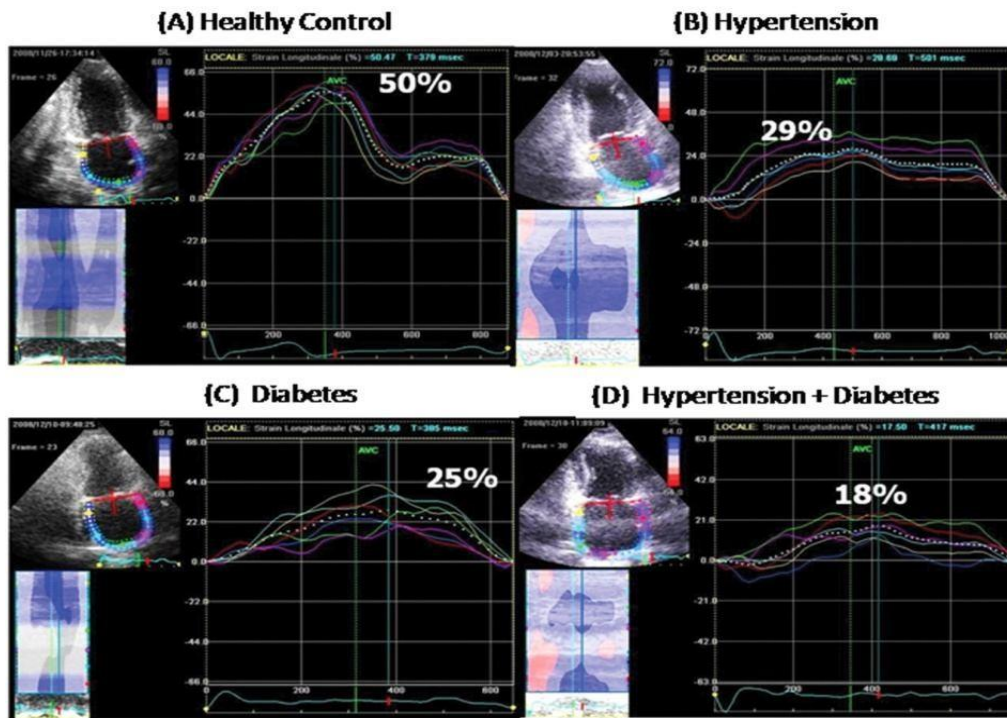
Left atrial function analysis by speckle-tracking echocardiography showing sample peak atrial longitudinal strain measurements in a healthy individual (A), a hypertensive patient (B), a diabetic patient (C), and a hypertensive and diabetic patient (D) with a preserved ejection fraction and no enlargement of the left atrium. Both hypertension and diabetes have a major impact on left atrial myocardial deformation. Coexistence of both conditions further impairs left atrial performance in an additive manner (44).
